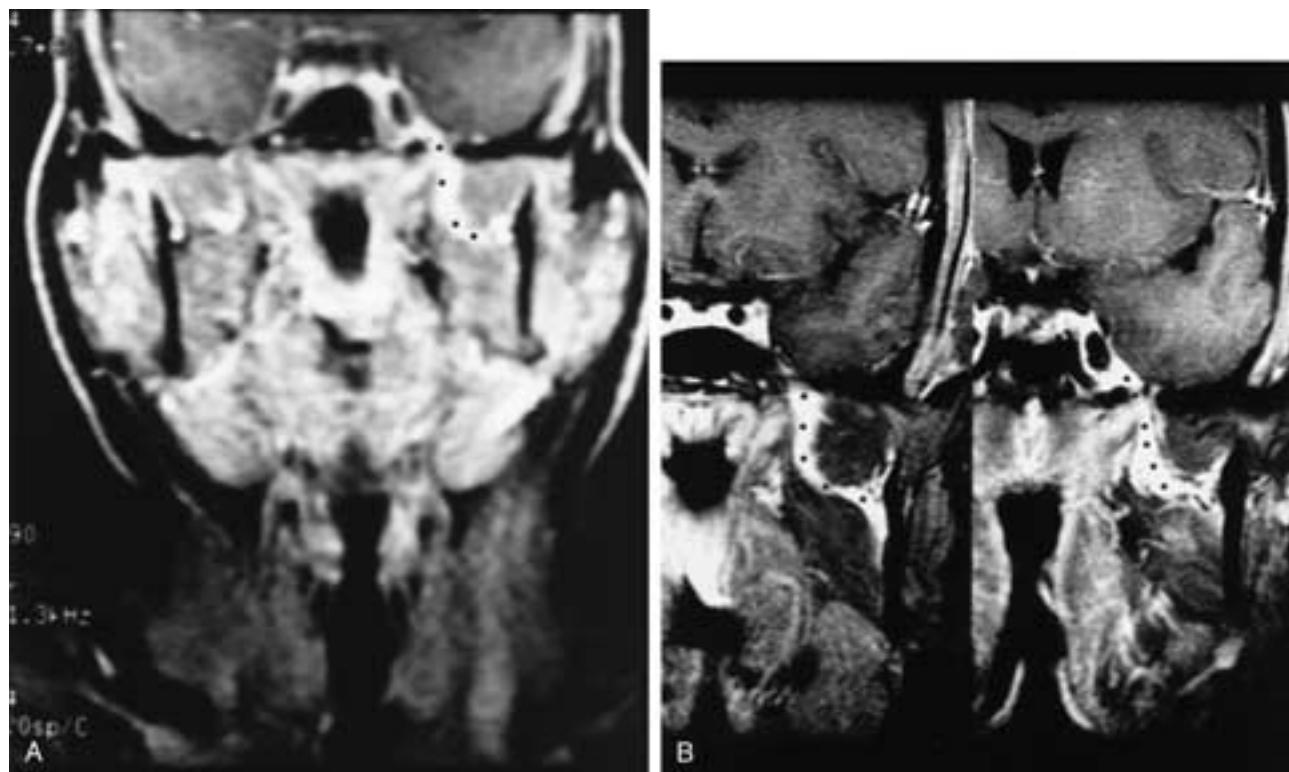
Squamous cell carcinoma of the left lower lip with PNS along the inferior alveolar branch of V₃. A, Coronal contrast-enhanced T1-weighted MR image without fat suppression obtained at an outside institution. Though visible, the perineural tumor along the proximal mandibular nerve and foramen ovale is hard to see (black dots). B, Repeat imaging with fat suppression; the tumor enhancement is far more conspicuous (black dots).
